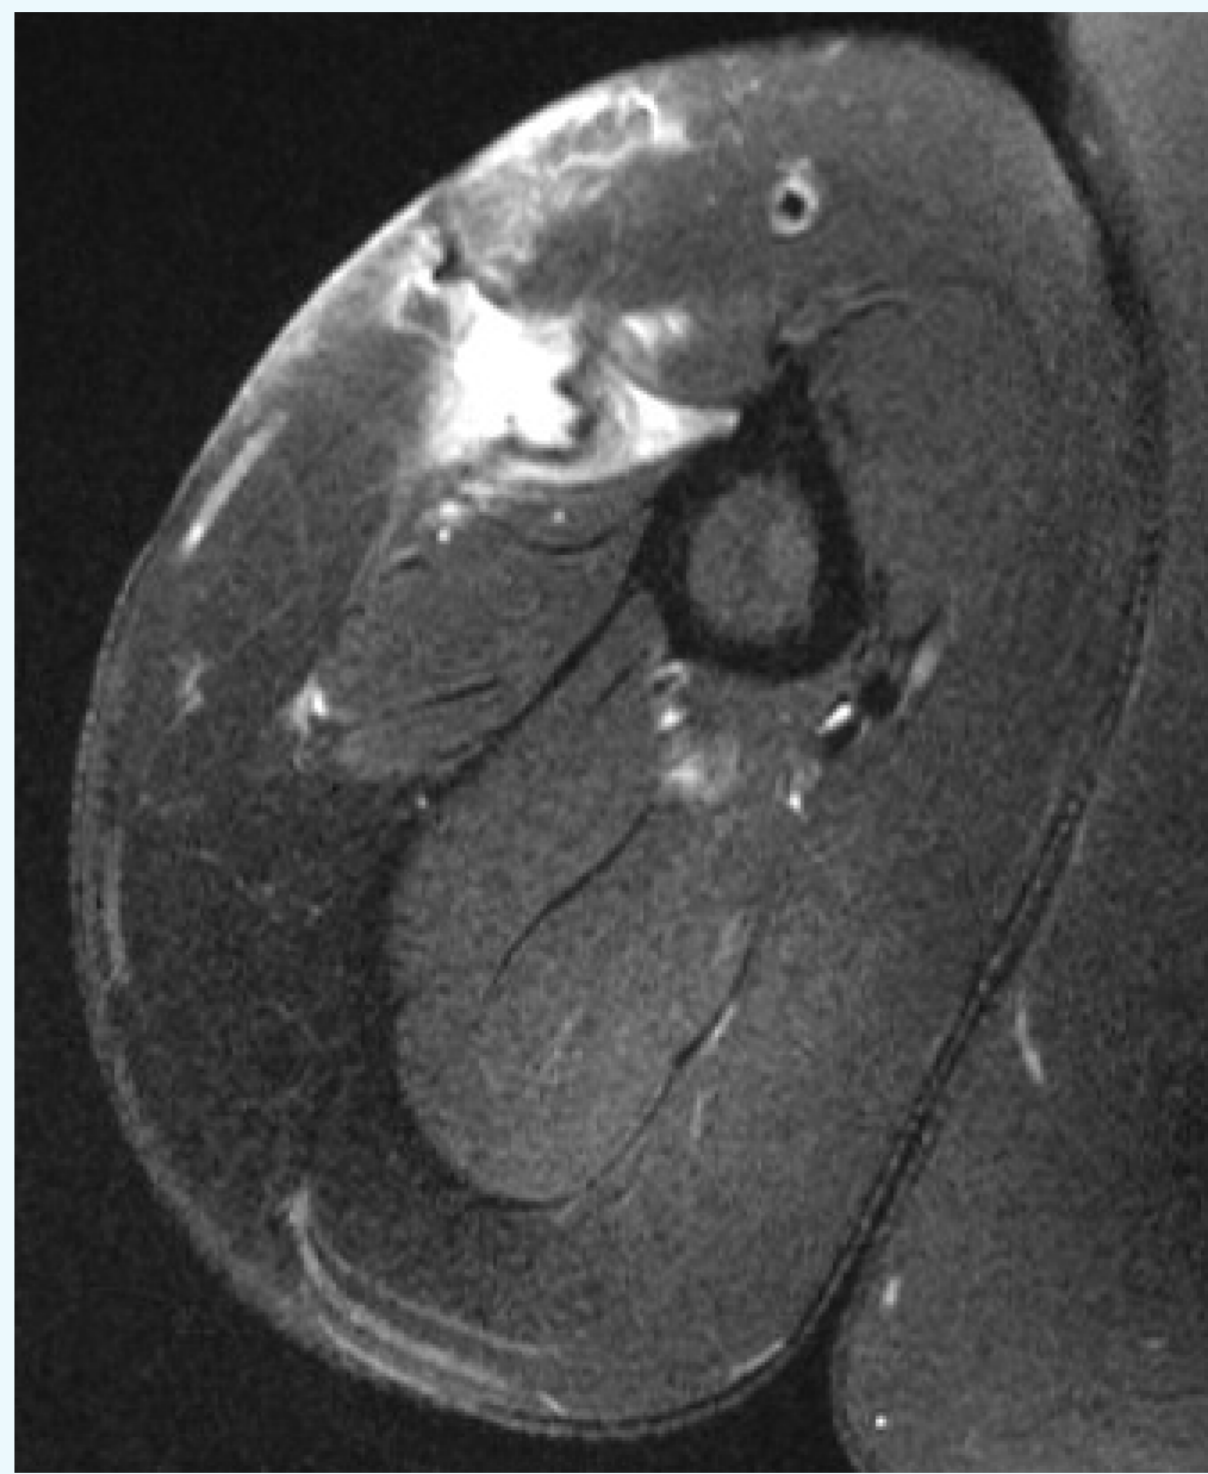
Nocardia veterana* abscess. T2-weighted magnetic resonance imaging demonstrates 2 cm abscess involving the superficial fascia of the right lateral deltoid muscle
